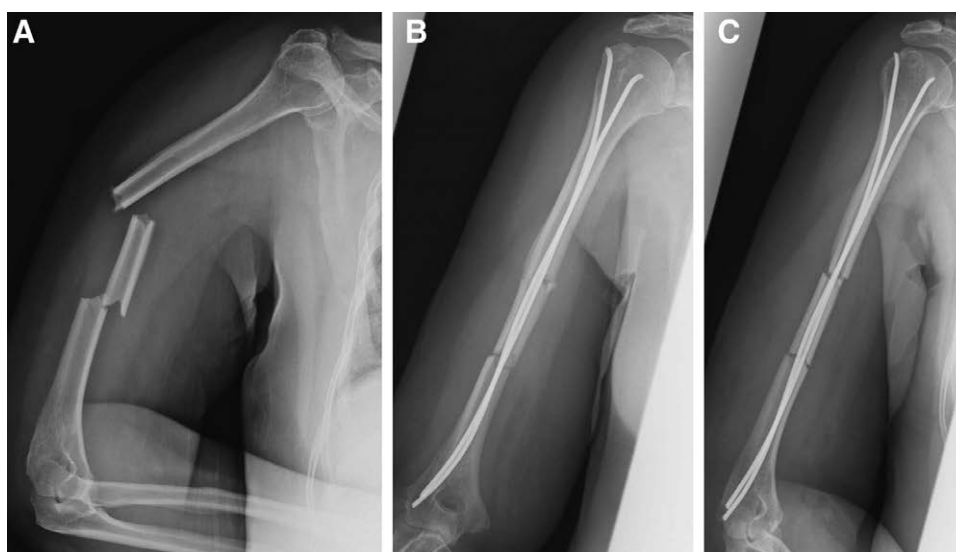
A 55-y-old woman with a segmental fracture of the humerus with severe narrowing of the intramedullary canal (<7 mm). A, Preoperative X-ray, (B, C) postoperative X-ray show two 2.5-mm titanium elastic nails that were inserted in a retrograde manner.
